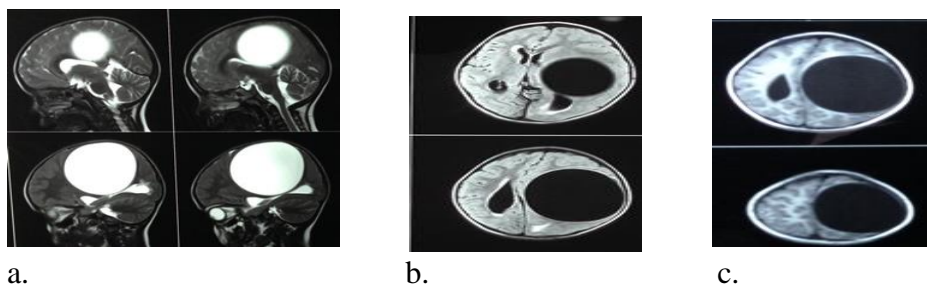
Pre-operative MR studies. a. T2- weighted MR picture showing left sided parietal HC. b. and c. Fluid attenuated inversion recovery (FLAIR) sequence MR picture showing left sided parietal HC.
